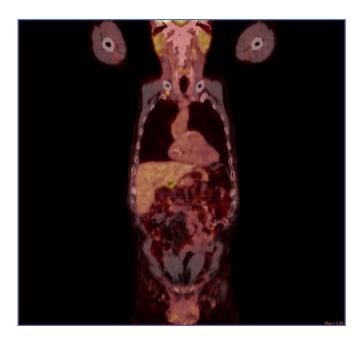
Fusion coronal reformatted images of a PET CT Scan show nodular radiotracer uptake in the region corresponding to the right costoclavicular ligament.
